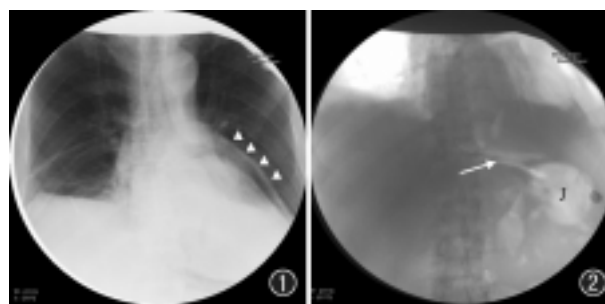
Chest X-ray showing the pneumopericardium (white arrows).
